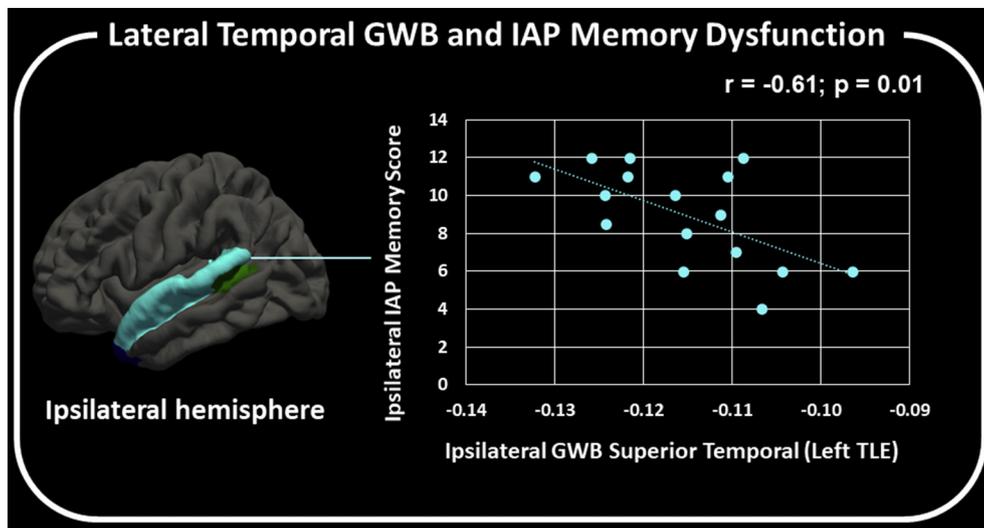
Cortical gray and white matter blurring (GWB), averaged across the superior temporal lobe, was inversely correlated with intracarotid amobarbital procedure (IAP) memory scores obtained from the ipsilateral hemisphere (i.e., when the contralateral hemisphere was anesthetized) in people with left MRI-negative temporal lobe epilepsy (TLE). Gray and white matter blurring scores range from -1 to 0 , with 0 representing the highest degree of blurring. Intracarotid amobarbital procedure memory scores range from 0 to 12 with 12 representing the highest score possible.
